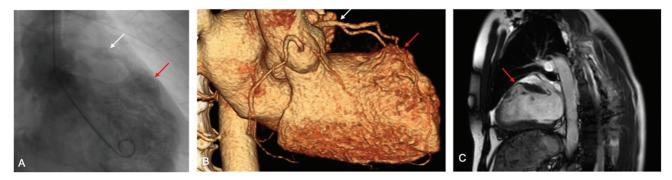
Imaging of the (A) left ventricle aneurysm (white arrow: left anterior descending, red arrow: aneurysm). (C) Coronary angiograph, (B) three-dimensional computed tomography scan, (D) magnetic resonance imaging scan.
